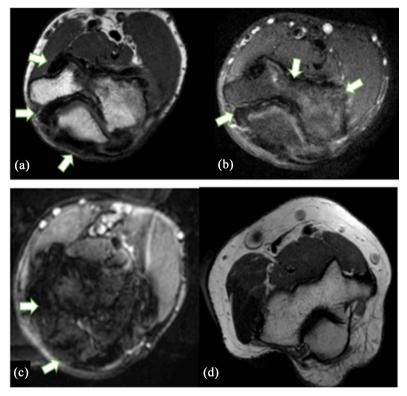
MRI of the left elbow: ulnar tunnel syndrome conflicting peri-nerve fibrosis of the ulnar nerve. Axial section T2 SE (a), axial section T1 SE FS (b), axial section T2 SE (c) normal elbow. Normal ulnar nerve (white circle). T1 and T2 hyposignal with peripheral fibrosis (T2 hyposignal) (white arrow). The ulnar nerve is followed in its normal course through the epitrochleo-olecranial defilement, which appears T1 and T2 hyposignal. Its caliber is discreetly increased, to a maximum of 10 mm, and its contours are blurred: moderate thickening of its fibers with no evidence of hypersignal. No visible continuity of the bony structures of the epitrochlear-olecranial canal. No ulnar nerve contrast after injection of gadolinium chelates, discrete peripheral contrast due to fibrosis.
